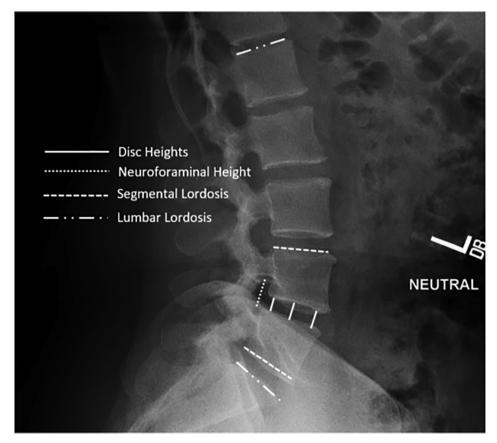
Standing lateral lumbar spine radiograph with superimposed lines demonstrating the measurements assessed in this study: disc heights (anterior, middle, posterior), neuroforaminal height, segmental lordosis, and lumbar lordosis.
